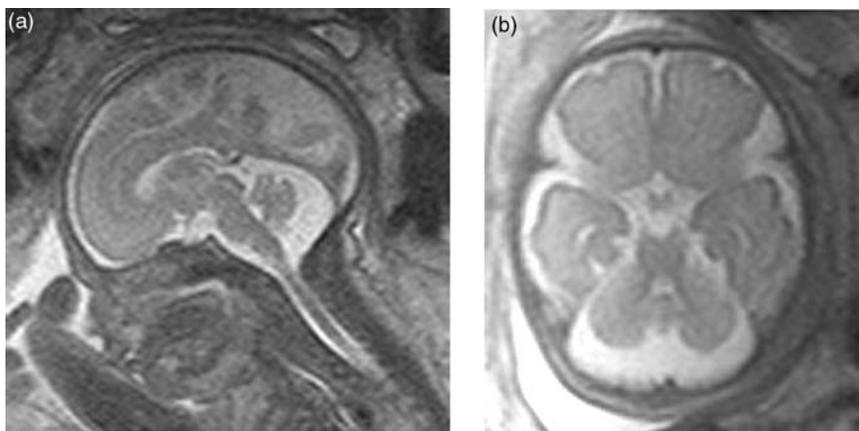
Dandy–Walker malformation and agenesis of the corpus callosum at 26 weeks gestational age. Sagittal (a), axial (b), and coronal (c) views demonstrate an elevated vermian remnant (v), small cerebellar hemispheres (white c indicated in the figure b), and wide continuity of the fourth ventricle with the large retrocerebellar space. Note the vertical orientation of the frontal horns (arrowheads) and absent corpus callosum. (d) Postnatally, a large interhemispheric cyst (black c indicated in the figure d) was visualized, which had not been noted prenatally on either ultrasound or MR imaging. At the time the cyst was present, the ventricles also were larger, suggesting that the cyst was at least partially formed secondary to increased intraventricular pressure. [(c) From Stroustrup Smith and Levine (33)]
